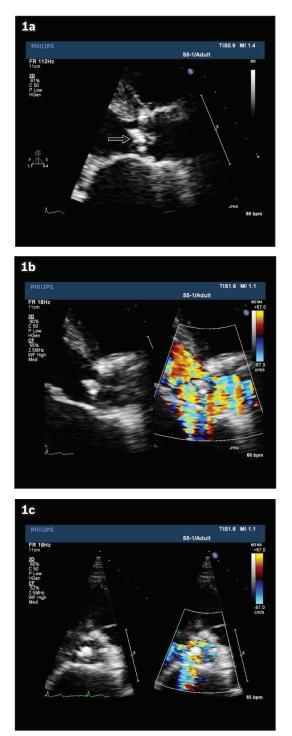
Parasternal long axis transthoracic echocardiography images show (a) flail non-coronary aortic valve leaflet (arrow); and (b & c) severe AR (colour jets).
